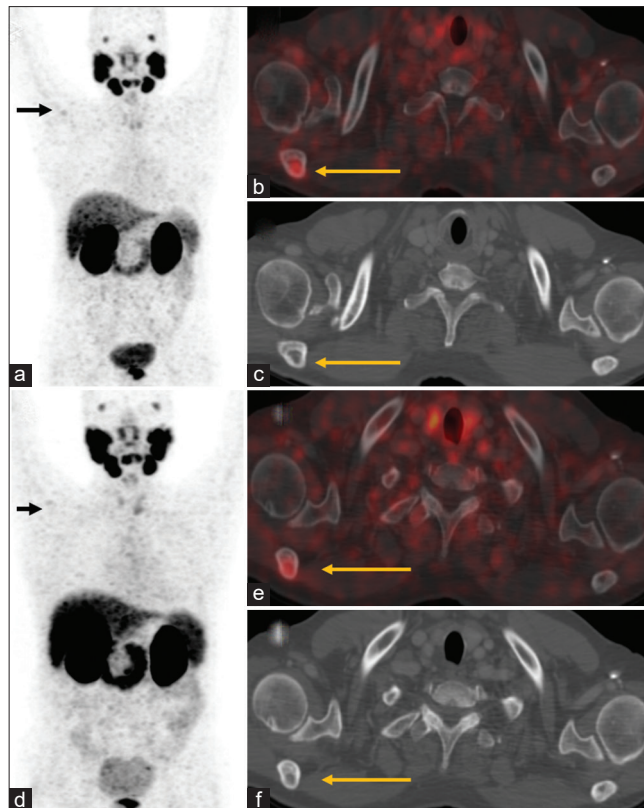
This is a case of a 70-year-old male patient with adenocarcinoma prostate (Gleason score 3+3=6) with a baseline serum PSA- 15.5 ng/ml. A 68Ga PSMA PET/CT scan reported increased tracer uptake in prostate and a well-defined lytic lesion in right scapula with low grade tracer uptake (SUVmax 4.37) (MIP (a), fused (b) & CT (c), respectively; arrows). Patient was kept on active surveillance. After 8 months, he presented with rising serum PSA (32.33 ng/ml) for which he underwent a repeat 68Ga PSMA PET/CT scan. The disease in prostate had no significant changes in size and PSMA uptake; nor, the right scapular lesion showed any increase in PSMA uptake (SUVmax 4.80) or lysis (MIP (d), fused (e) & CT (f), respectively; arrows). The patient also complained of vague pain in right shoulder region which remain unchanged. Biopsy from the scapular lesion suggested aneurysmal bone cyst
